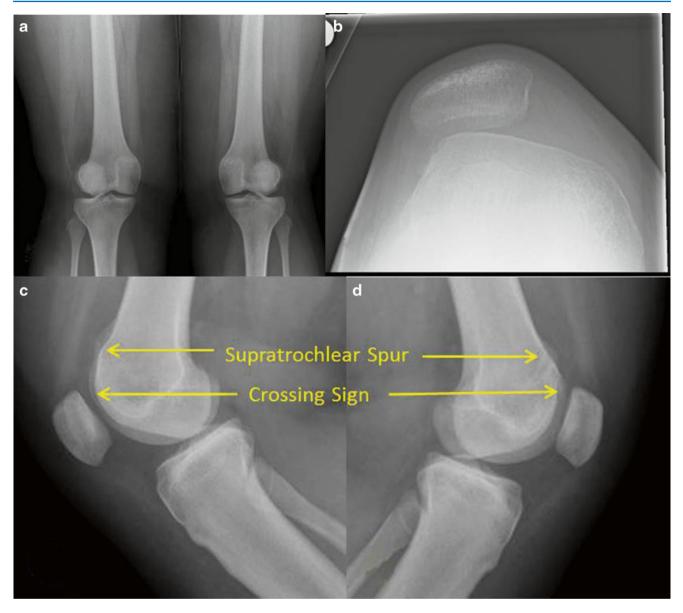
(a–d) PA, merchant (R knee), and lateral radiographs, demonstrating Dejour type D trochlear dysplasia bilaterally (*arrows*), more severe on the left. The crossing sign represents the point at which the trochlea is flattened
